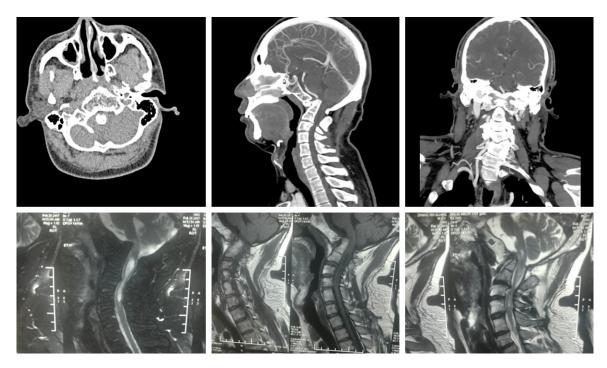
Images provided by CT before surgery.
